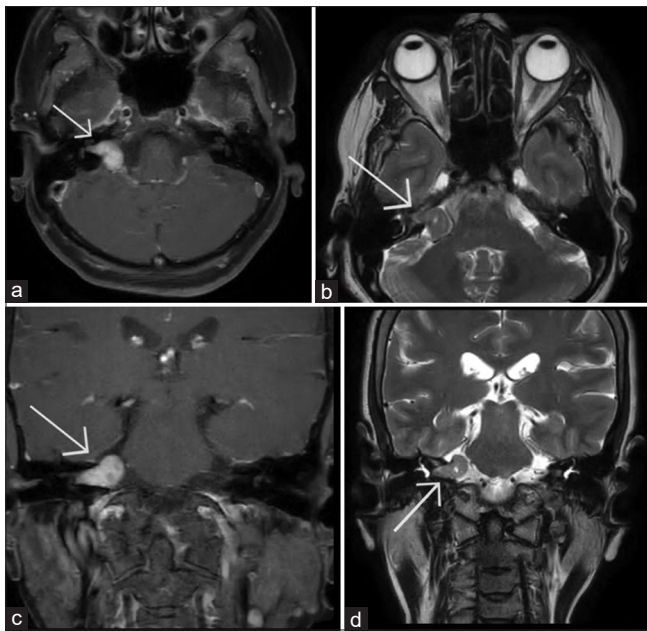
(a) T1-weighted axial, (b) T2-weighted axial, (c) postcontrast T1-weighted coronal, and (d) T2-weighted coronal magnetic resonance images showing a right-sided vestibular schwannoma in a patient with hemifacial spasm
